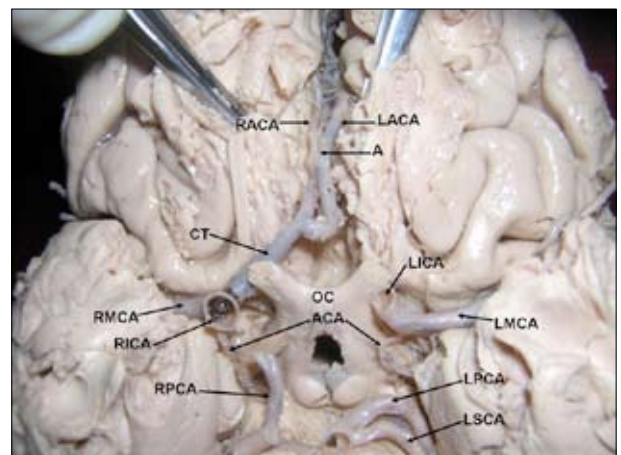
Photograph of closer view of interpeduncular fossa showing the anomalous arteries. Color version of figure is available online. (*RACA*: right anterior cerebral artery; *CT*: common trunk giving rise to right and left anterior cerebral arteries; *LACA*: left anterior cerebral artery; *A*: anastomosis between to anterior cerebral arteries; *RICA*: right internal carotid artery; *LICA*: left internal carotid artery; *OC*: optic chiasma; *RMCA*: right middle cerebral artery; *LMCA*: left middle cerebral artery; *ACA*: anterior choroidal arteries; *RPCA*: right posterior communicating artery; *LPCA*: left posterior communicating artery; *LSCA*: left superior cerebellar artery)
